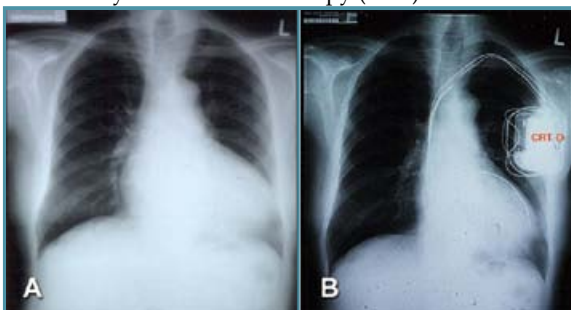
Chest radiographs of a patient with dilated cardiomyopathy with ejection fraction of 25%, before (A) and after (B) cardiac resynchronization therapy with defibrillator (CRT-D). This shows significant reduction in heart size. A 3 lead system, right atrial, right ventricle and left ventricle.
